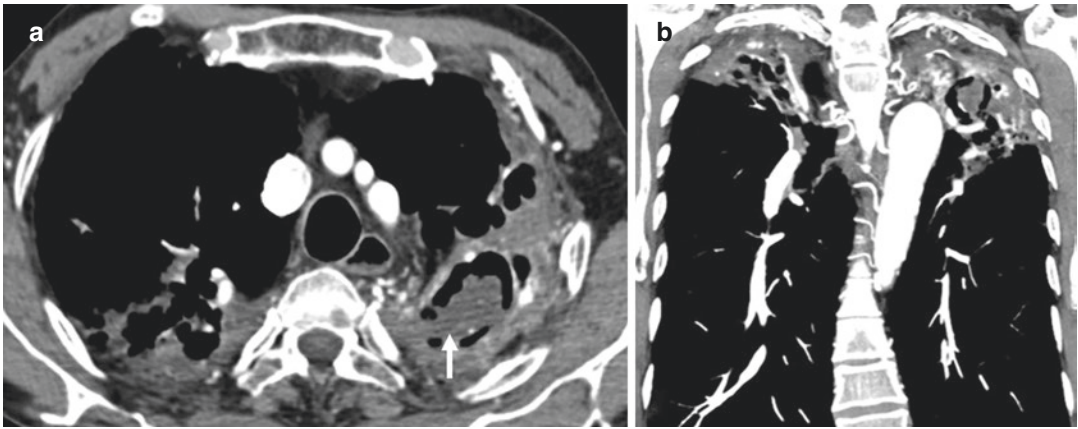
Aspergilloma in a 74-year-old patient with a history of pulmonary tuberculosis. (a) Axial and (b) coronal CT angiography images show resultant lesions in the upper lobes with a left cavity containing a mycetoma (arrow in a). Note the surrounding systemic bronchial and nonbronchial bilateral hypervascularization, particularly around this cavity (b)
